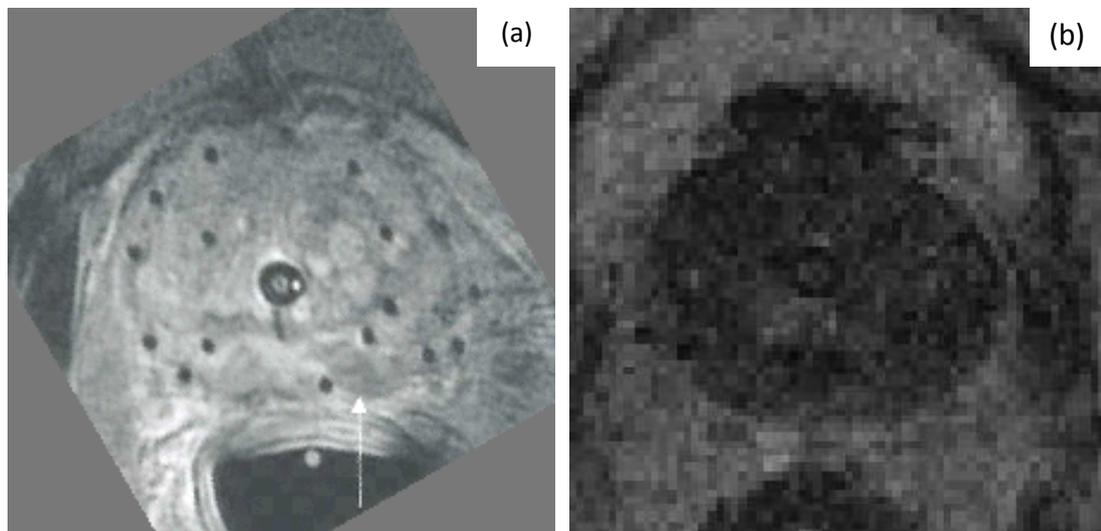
(a) Adapted from Menard *et al* 2004. T2 endorectal coil MR image in patient with natural hips. Prostate and implanted needles are well defined. (b) SCGH transverse T2 MR image in patient with bilateral prosthetic hips; poorly-visualised prostate and implanted needles not detectable. Note reduced spatial resolution and reduced contrast resolution.
